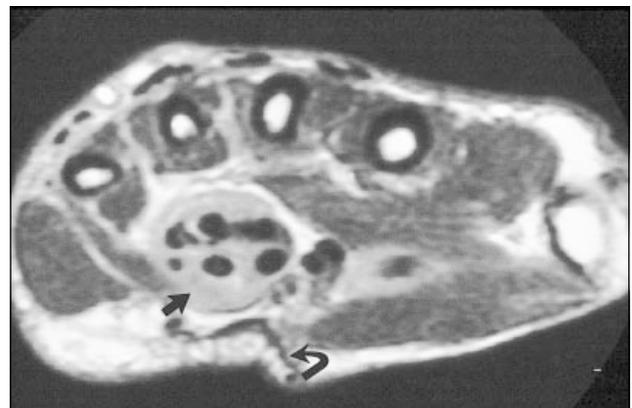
Patient with longstanding rheumatoid arthritis and carpal tunnel syndrome (postcontrast-enhanced axial T1-weighted image [TR 380 ms/TE 19 ms]). The tendons in the carpal tunnel are completely surrounded by a large quantity of enhancing pannus (arrow), producing bulging of the soft tissues anteriorly. Patient had previously undergone a carpal tunnel release (curved arrow). The dorsal tendon sheath shows no evidence of pannus or fluid distension.
